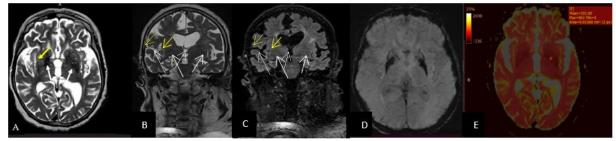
Figure 2: Brain MRI in a 70-year-old patient with a history of parkinsonian syndrome for 2 years. Axial (A), coronal (B) T2 and coronal T2 FLAIR (C) sections shows disharmonious bilateral widening the fronto-parietal cortical sulcus and a margination of the putamen appearing as a posterior hypo intensity in T2 and FLAIR sections (white arrow) with a hyperintense T2 border (yellow arrow). We note on the susceptibility sequence (D) a hypo intensity on the posterior surface of the putamen with a high ADC value in the diffusion sequence (E) related to an iron over deposition. Consistent with an AMS-p
